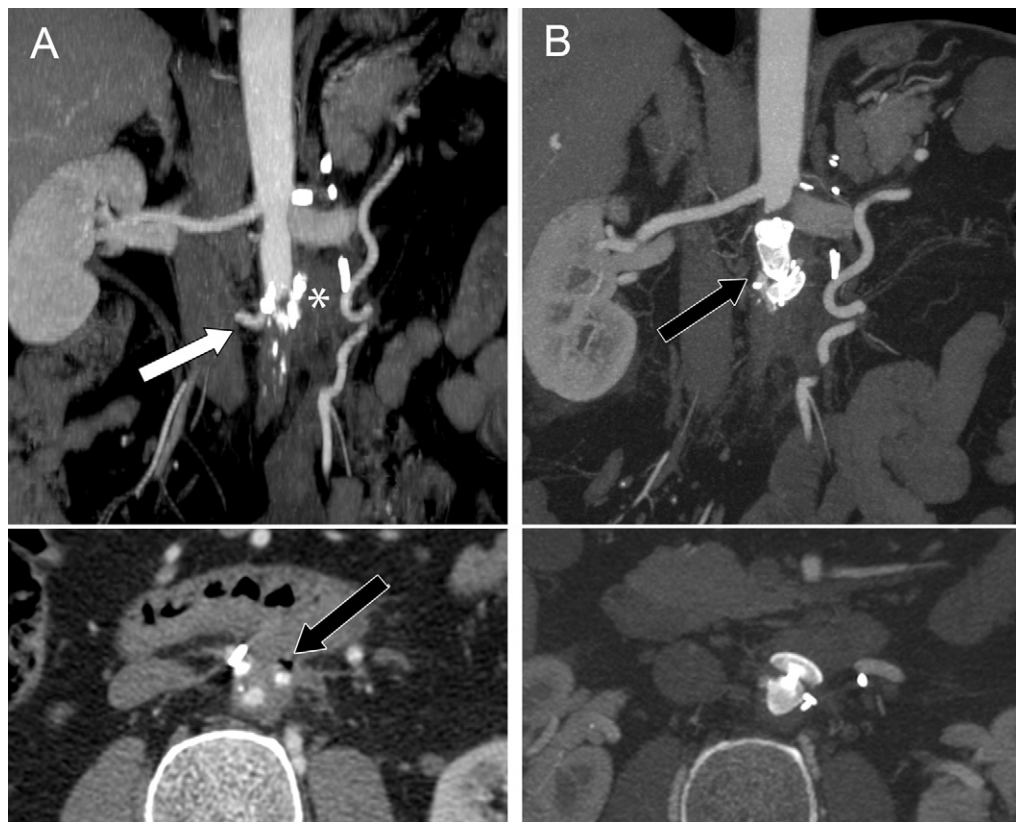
A, Multiplanar reconstruction of preoperative computed tomography (CT) scan (*top*), showing abdominal aortic occlusion, with a residual patent 3-cm-long infrarenal aortic stump. Of note, left infrarenal periaortic collection (*asterisk*) and a patent right lumbar artery (*white arrow*). On axial image (*bottom*), an air bubble surrounding the aorta is evident (*black arrow*). B, After deployment of a 18-mm Amplatzer Plug II (*top*; *black arrow*) into the infrarenal aortic stump, CT scan shows thrombosis of the aorta just below the origin of the right renal artery. Also, periaortic collection is less evident (*bottom*).
